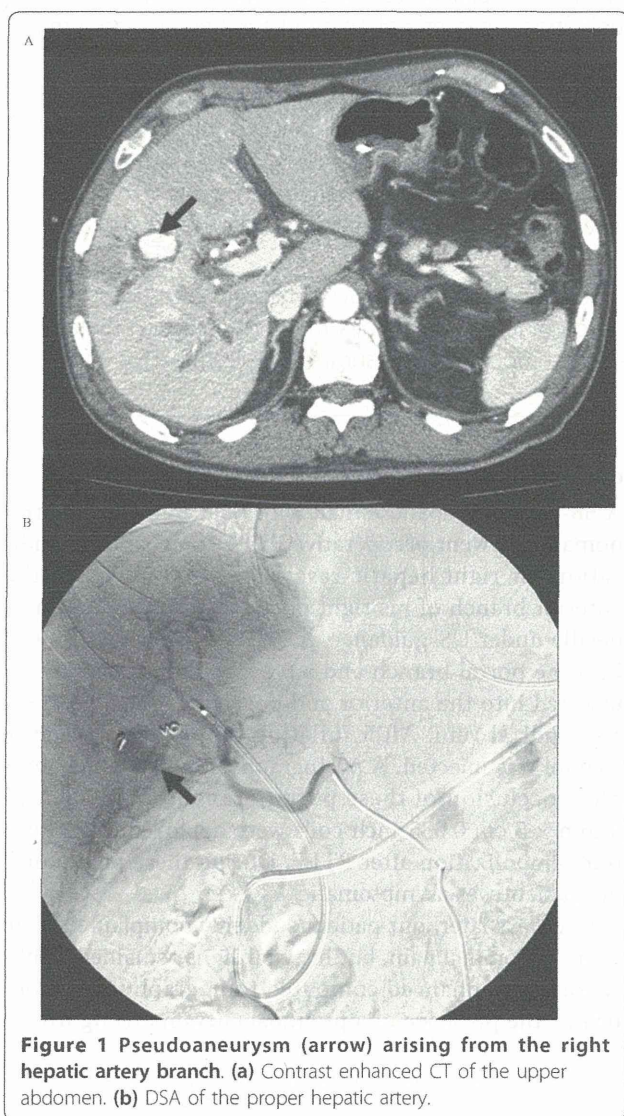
Pseudoaneurysm (arrow) arising from the right hepatic artery branch. (a) Contrast enhanced CT of the upper abdomen. (b) DSA of the proper hepatic artery.
